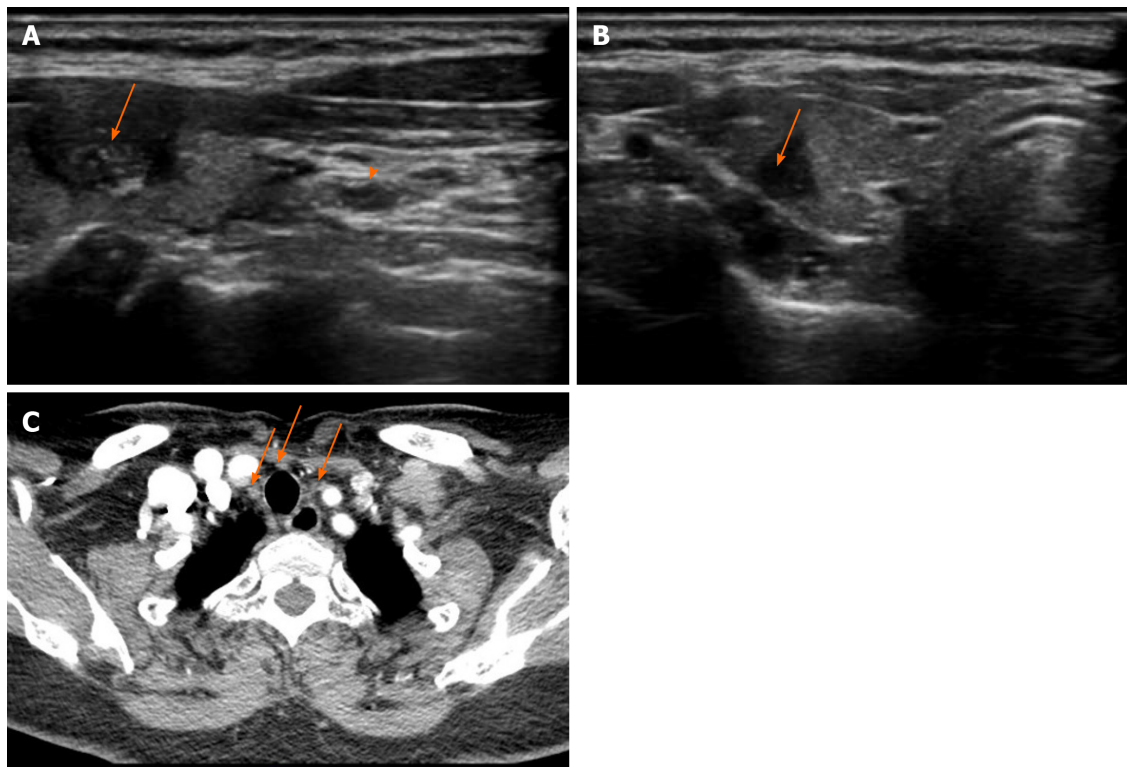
Ultrasound and contrast-enhanced computed tomography images obtained 3 mo after radiofrequency ablation for papillary thyroid carcinoma. A: The left thyroid nodule (arrow) (6 mm × 8 mm × 12 mm) with hypoechogenicity, unclear margins, and scattered small calcifications on ultrasound was classified as Thyroid Imaging Reporting and Data System stage 4c. Metastatic central lymph nodes (arrowhead) were also detected; B: The right thyroid nodule (5 mm × 5 mm × 7 mm) with hypoechogenicity and unclear margins on ultrasound was classified as Thyroid Imaging Reporting and Data System stage 4a; C: Central lymph node metastasis was detected using contrast-enhanced computed tomography.
